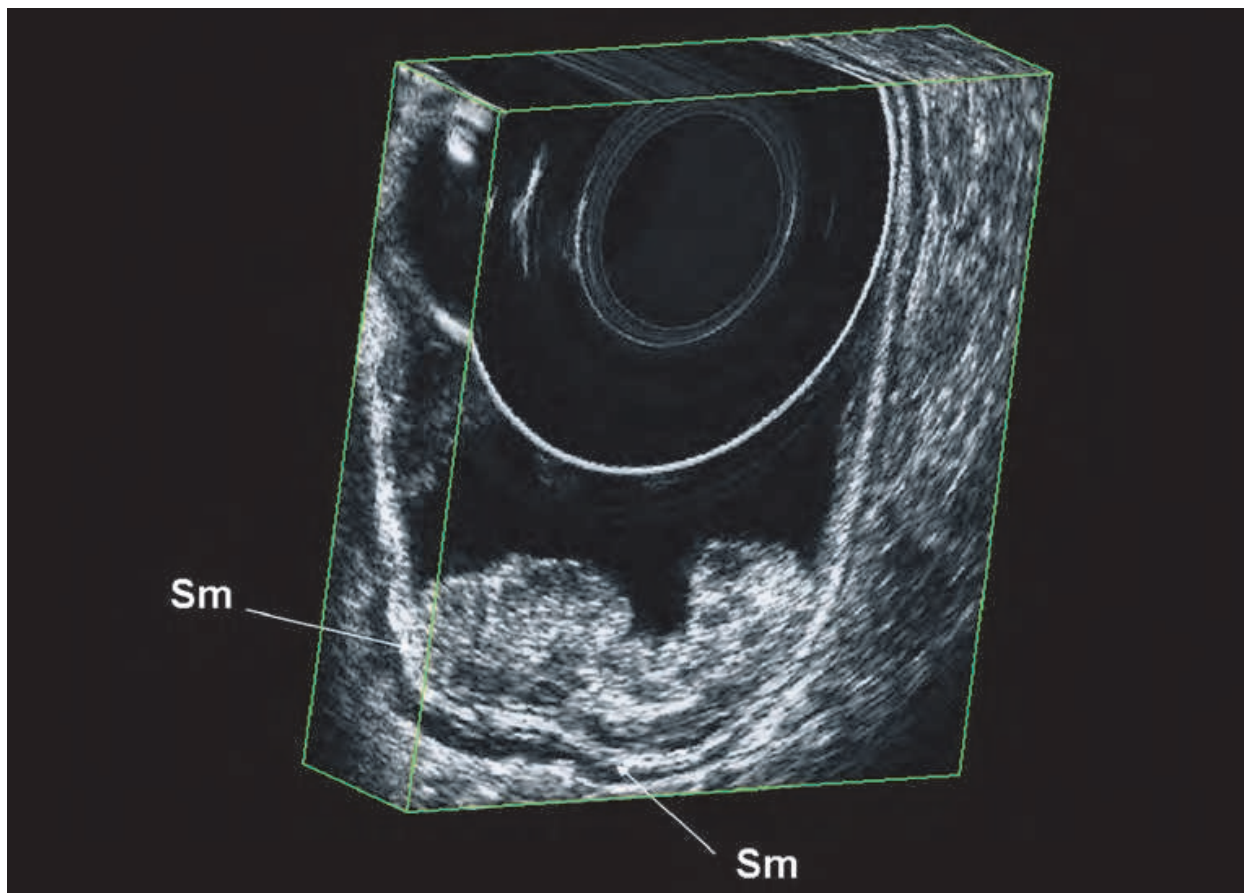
Villous rectal lesion are characterized at ultrasonography by a broadening of the first hypoechoic layer and an intact hyperechoic submucosal interface
